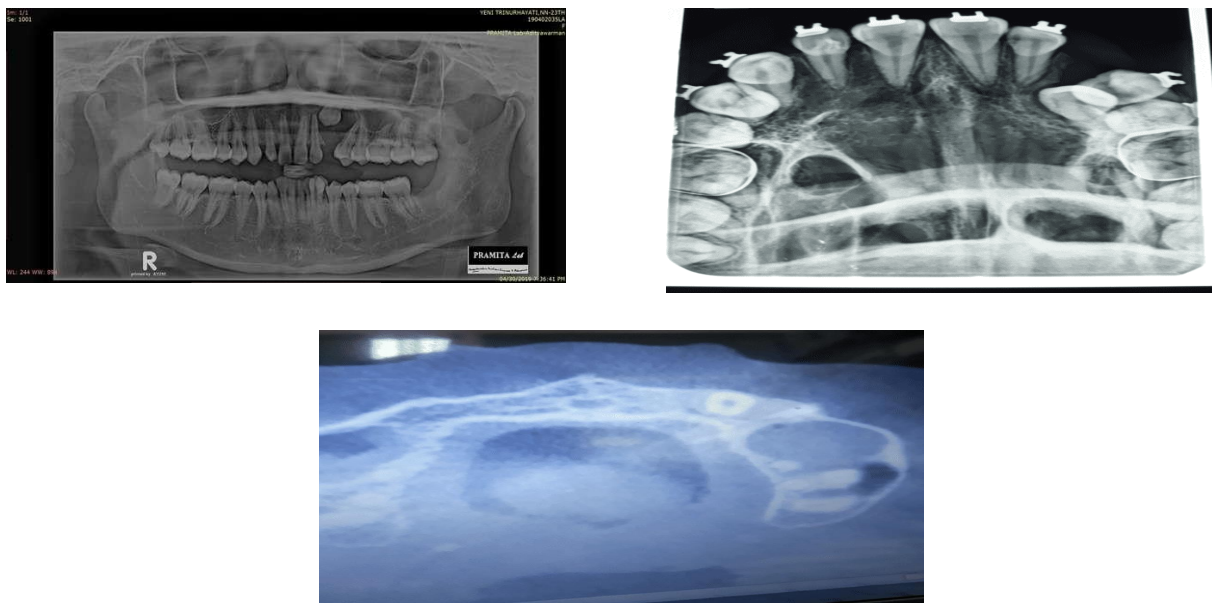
Panoramic photo and Proyeksi oklusal and CBCT
